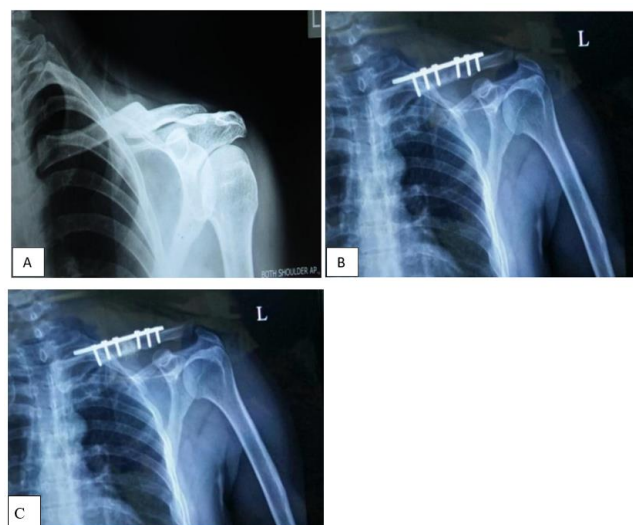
A: Pre-op x-ray; B: Immediate post op x-ray; C: Follow-up at 6 months
